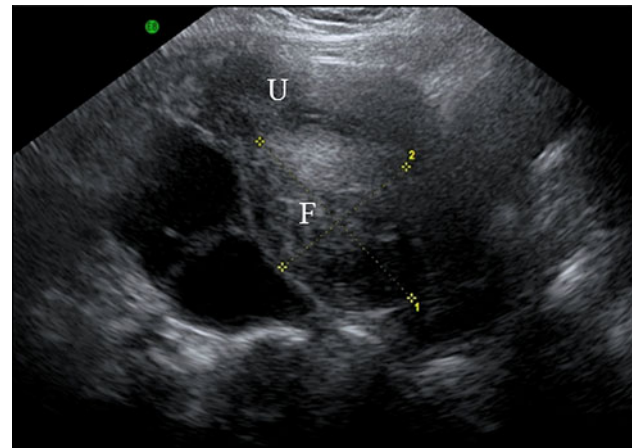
Transvaginal ultrasound scan (TVUS) showing a transverse view through the uterus (U). There is a large, well marginated subserosal fibroid (F) posteriorly which is heterogeneous and hyperechoic to surrounding myometrium
